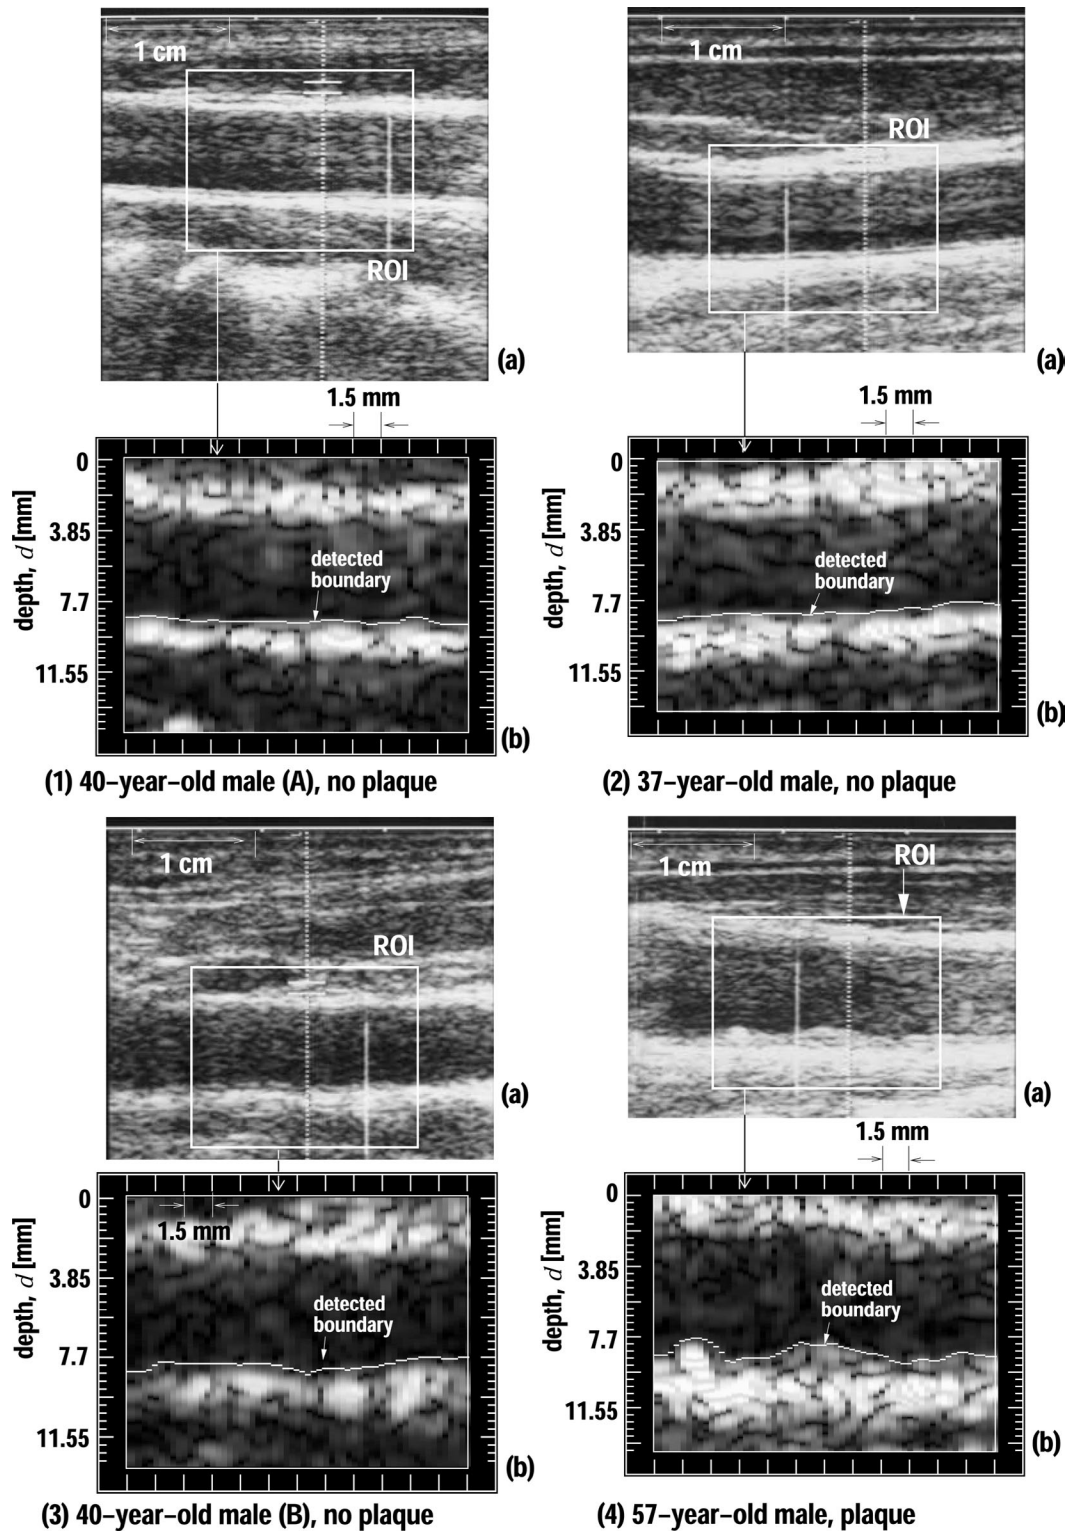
Detected lumen-intima boundaries for four subjects. (a) B-mode image obtained by standard ultrasonic diagnostic equipment. (b) B-mode image reconstructed from the amplitude, $|z(t; d; \ell)|$, of the quadrature demodulated signal. (1) 40-year-old male (A) without atherosclerotic plaque. (2) 37-year-old male without atherosclerotic plaque. (3) 40-year-old male (B) without atherosclerotic plaque. (4) 57-year-old male with atherosclerotic plaque.
